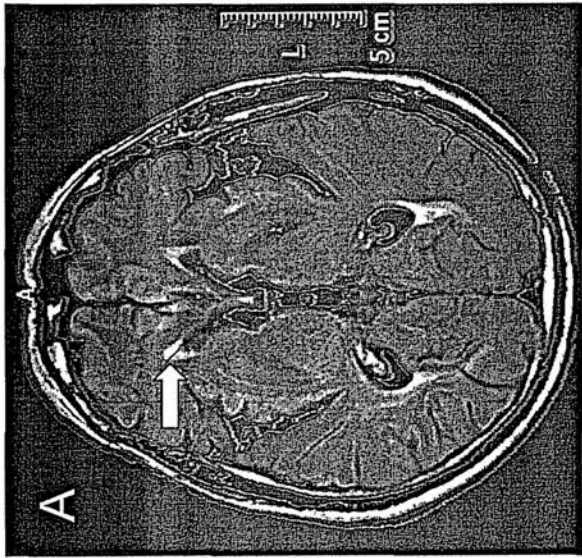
The diameter measurements of WMC on FLAIR MRI and CT. The arrows show the lesions.
